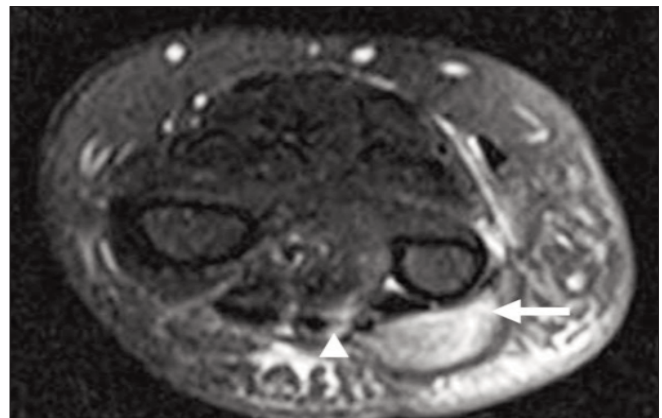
MRI of the right forearm. STIR axial sequence showed diffuse thickening of the common extensor tendon (→) and an abscess along the extensor carpi ulnaris tendon (→)
